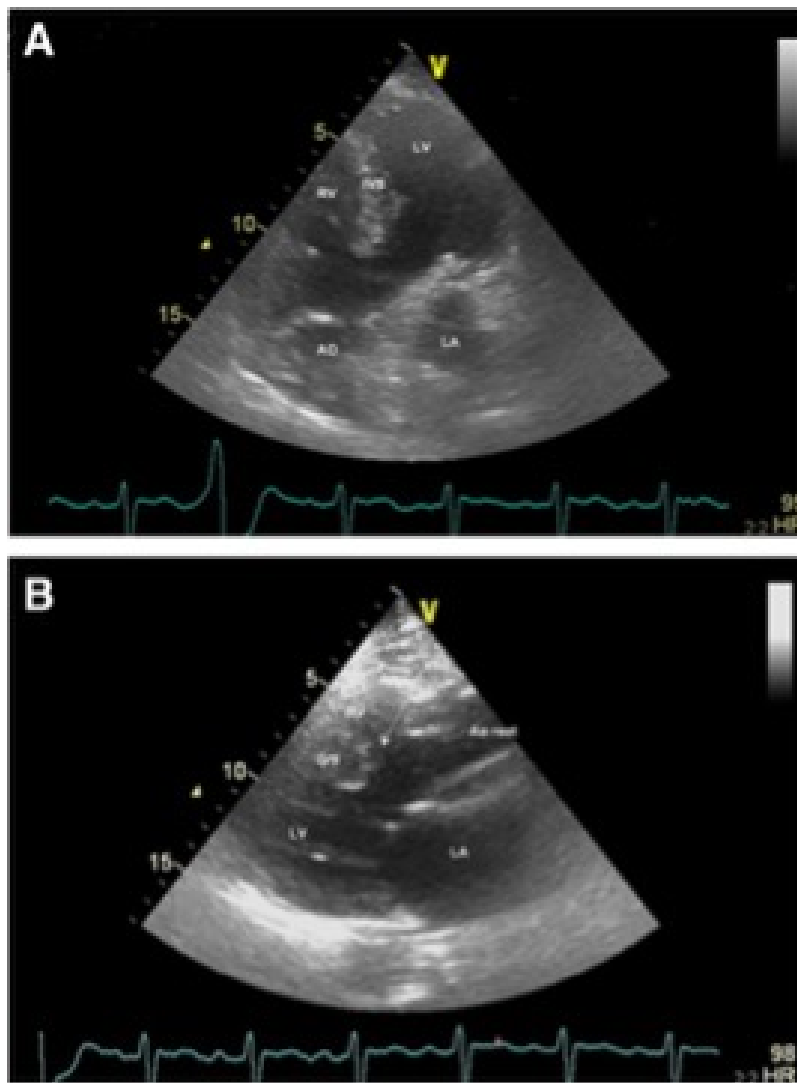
Tetralogy of Fallot diagnosis supported using transthoracic echocardiogram. “A: Five chamber view with the presence of the ventricular septal defect (VSD) and the overriding aorta over the septum. B: Parasternal long axis view revealing the VSD, the overriding of the aorta over the septum and also the right ventricle (RV) hypertrophy. AO, aorta; IVS, interventricular septum; LA, left atrium; LV, left ventricle.”¹
